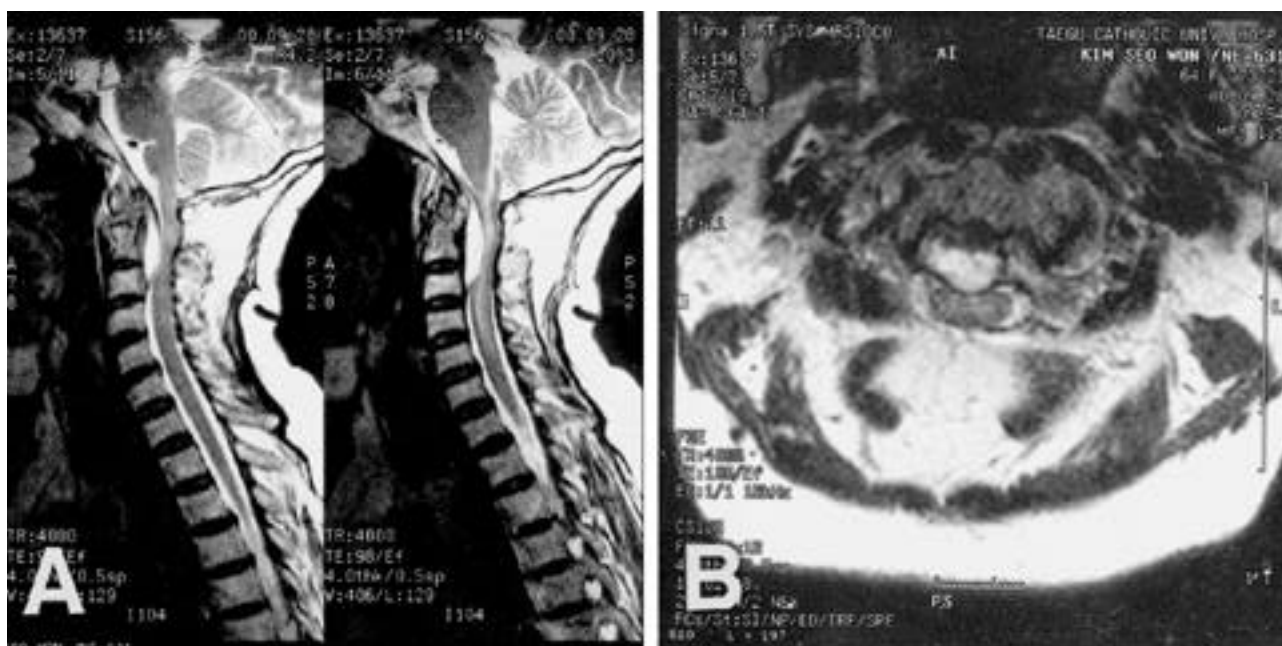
Sagittal(A) and axial(B) cervical MRI reveals a large anterior epidural abscess and cervical spondylitis at upper cervical level.
